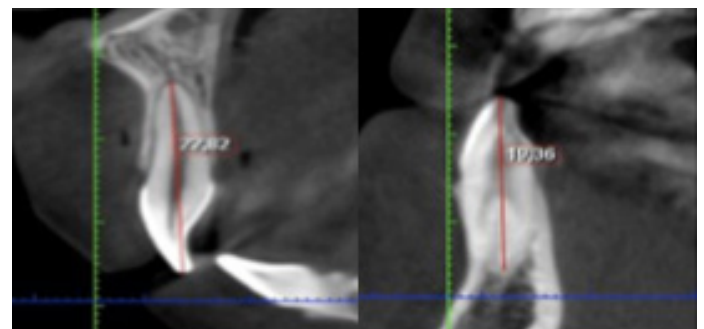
Cone-beam computed tomography images showing the length measurement in the sagittal section.
